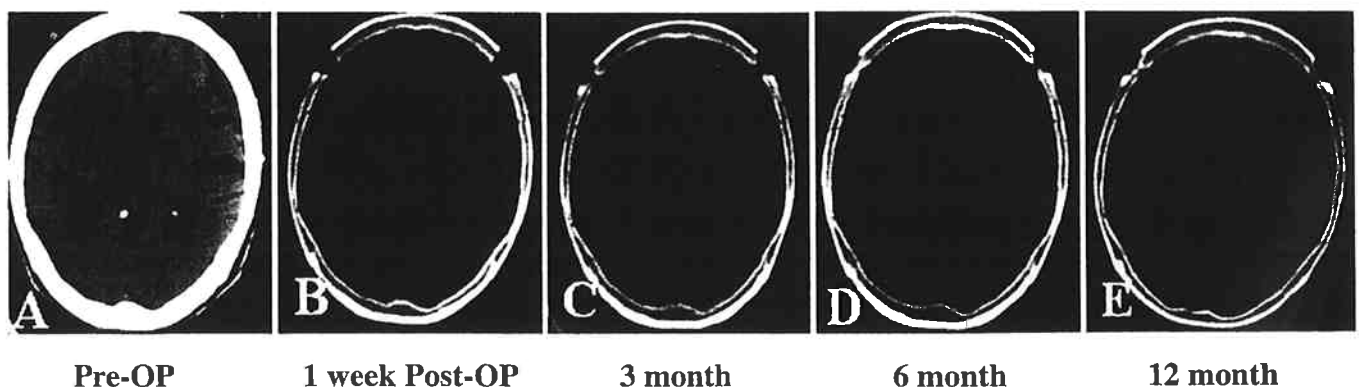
A, preoperative CT scan of bilateral subdural hematoma of an 83-year-old patient. B, subsequent CT scan after release of hematoma and reconstruction with two burr plugs (blood coated and fibrin sealed). CT
